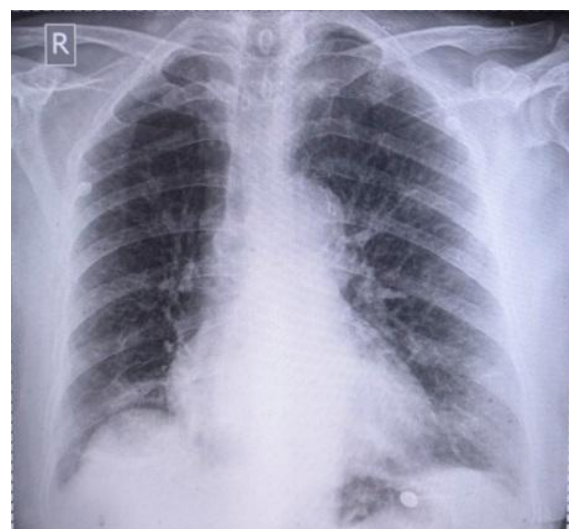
Chest X-ray on the third day after pigtail insertion
